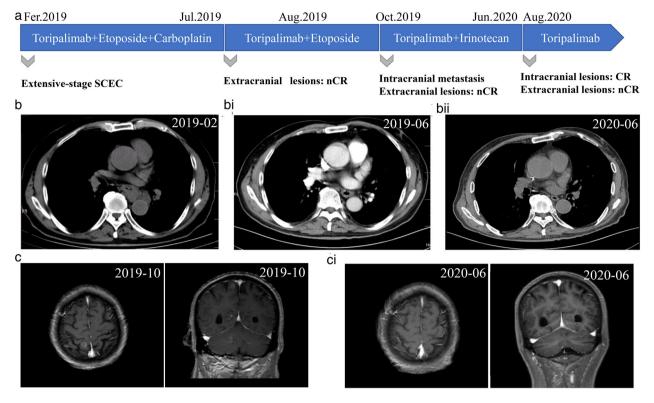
(a) Timeline of treatment; (b) Computed tomography (CT) scan before therapy; (bi) CT scan showing a near complete response (nCR) after six cycles of treatment; (bii) CT scan showing the patient was in a stable condition after 16 months of treatment; (c) Magnetic resonance imaging (MRI) showing intracranial metastasis in October 2019; (ci) MRI showing the intracranial lesions achieved a complete response (CR) after treatment.
